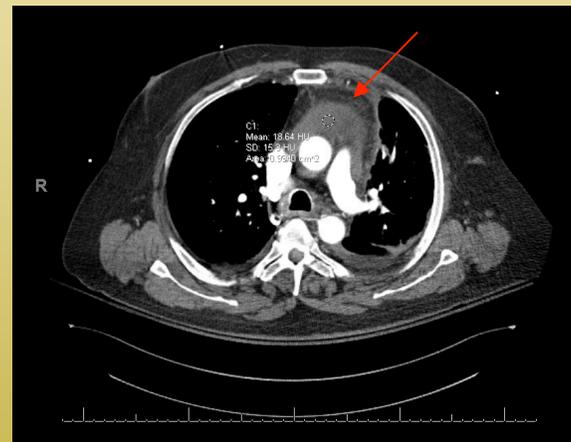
CTA chest/abd/pelvis showing pericardial effusion prior to fluid removal
